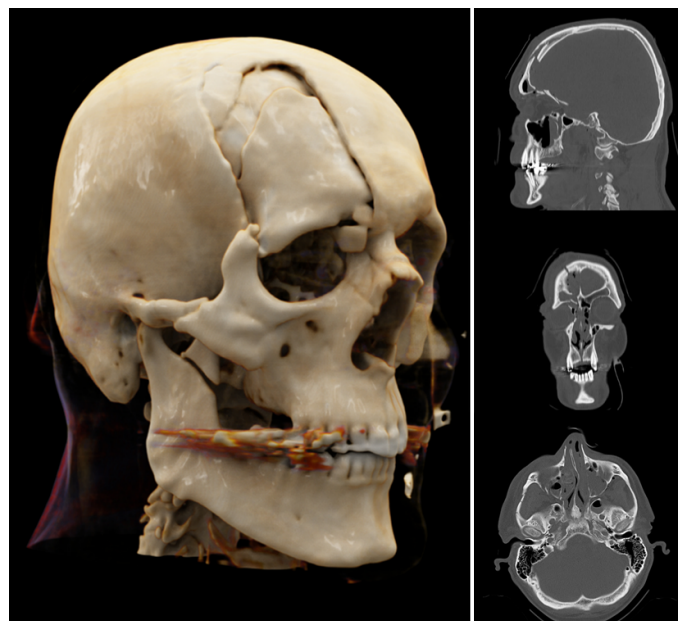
Three-dimensional visualization of the polytrauma CT scan using cinematic rendering
